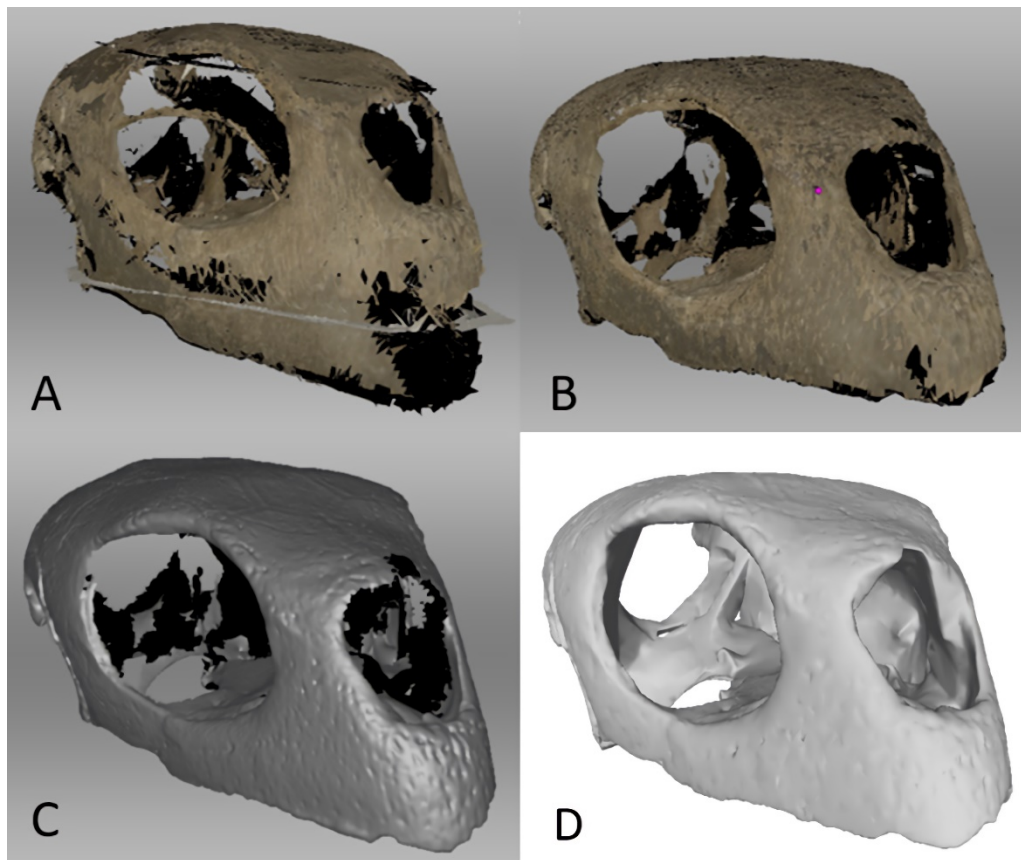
Surface scanned *Chelonia* cranium (A) prior to Global Registration in Artec Studio 14 Professional, (B) after Global Registration and outlier removal in Artec Studio 14 Professional, (C) after Sharp Fusion in Artec Studio 14 Professional, which converts the scans into an STL file, and (D) the same STL file in MeshLab 2020.06 after surface editing in Artec Studio 14 Professional and Blender 2.82 to close gaps in the model and better match the geometry of the CT files.
